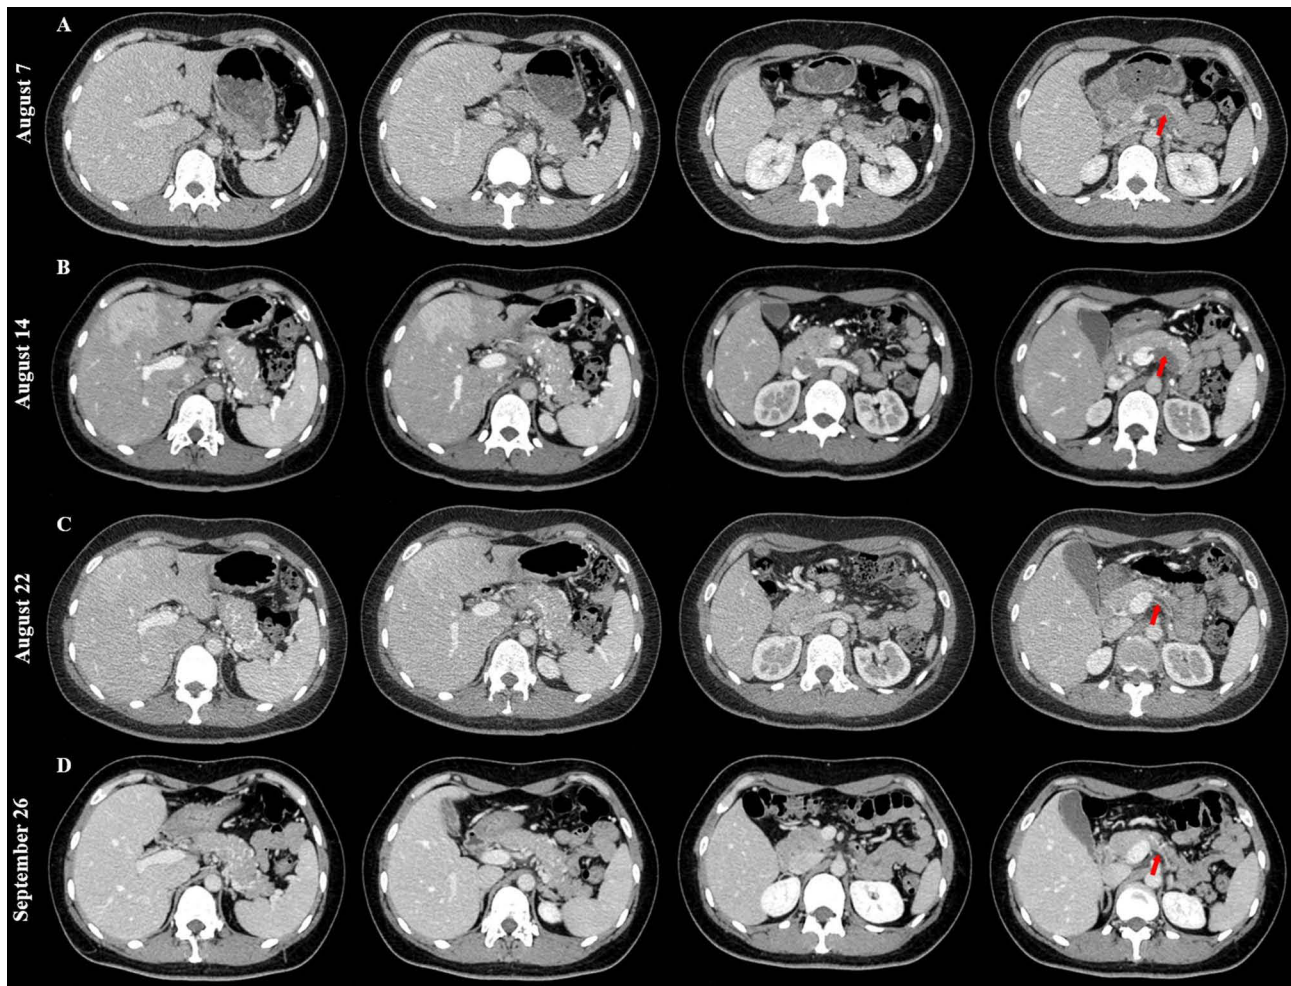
Contrast-enhanced CT images performed on August 7 (A), August 14 (B), August 22 (C), and September 26 (D) showing change of isolated splenic vein thrombosis (red arrow).
